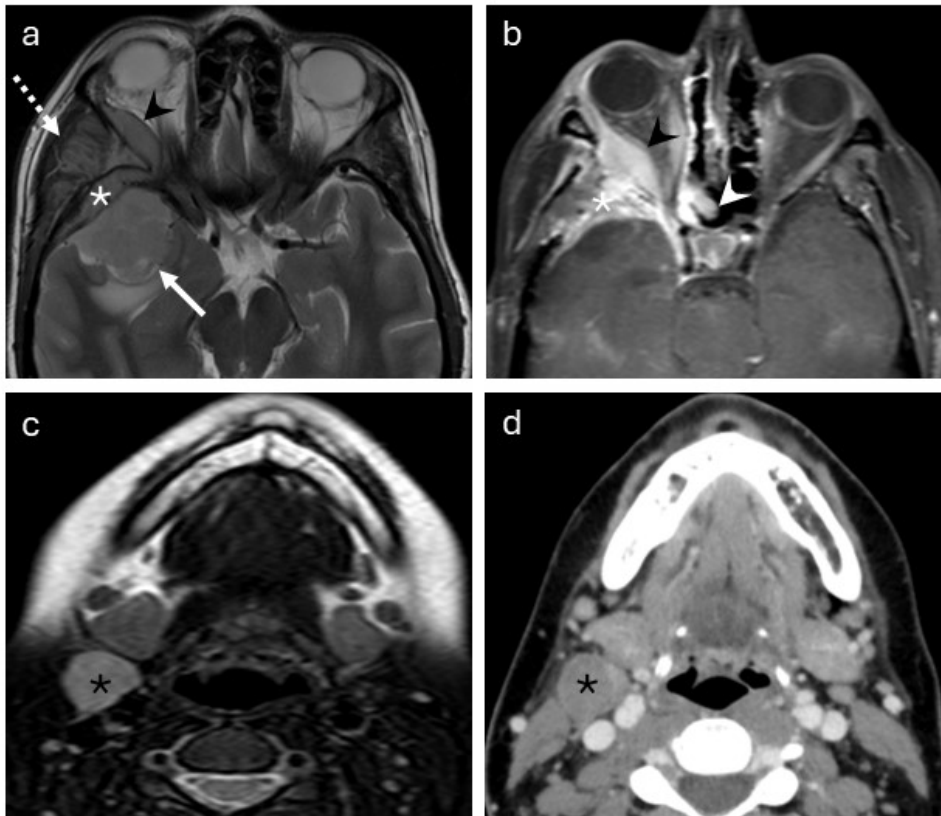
Meningioma with locoregional extracranial extension and distant nodal metastasis. The initial MRI (a) shows a solid extra-axial mass in the right middle cranial fossa (solid arrow) involving the right sphenoid bone (white asterisk), right temporalis muscle (dashed arrow), and right orbit (black arrowhead). MRI scans obtained post-treatment (b & c) reveal tumor progression with extension into the right sphenoid sinus (white arrowhead) and a T2-hyperintense mass within the right carotid space (black asterisk). A subsequent neck CT (d) shows an enlarged hypo-enhancing 4 cm right internal jugular chain lymph node (black asterisk); retrospectively, this node has been abnormal on earlier imaging.
